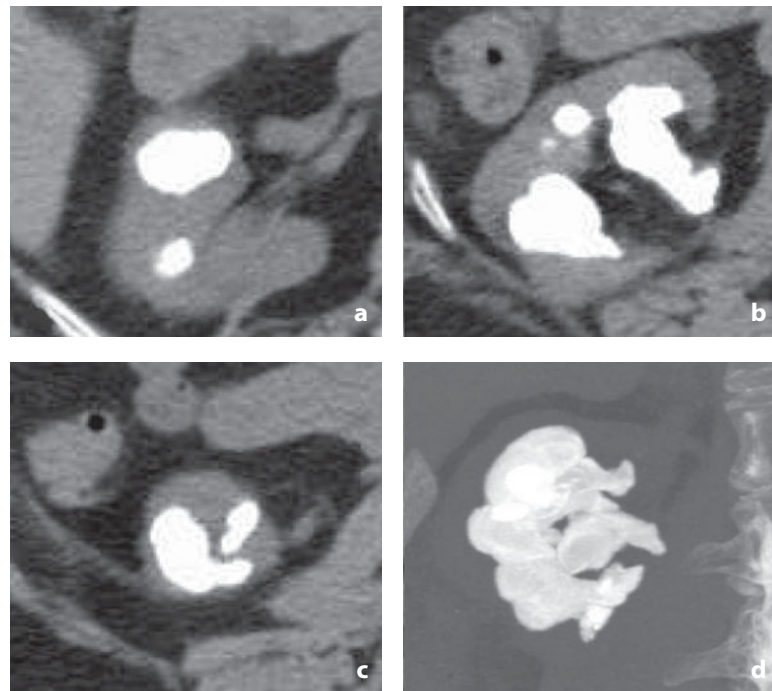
Nonenhanced CT. Staghorn calculus. a-c Kidney with staghorn calculus without dilatation of the calices distally in the native axial images and coronal MIP reconstruction (d)
